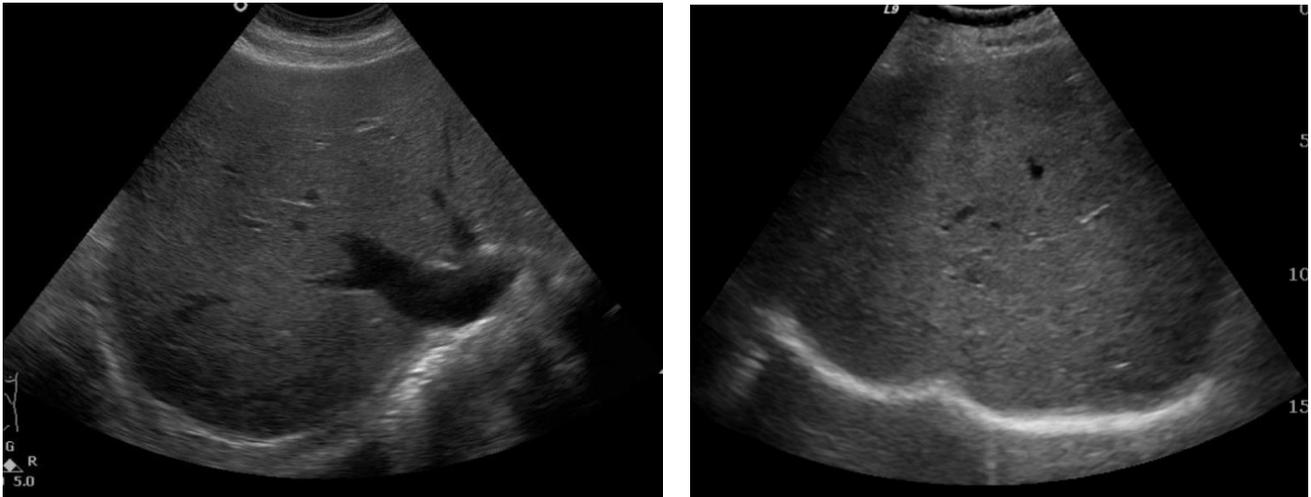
Ultrasound of patient T.K. echo picture of liver cirrhosis. Portal hypertension. Splenomegaly. Significant amount of ascites.
